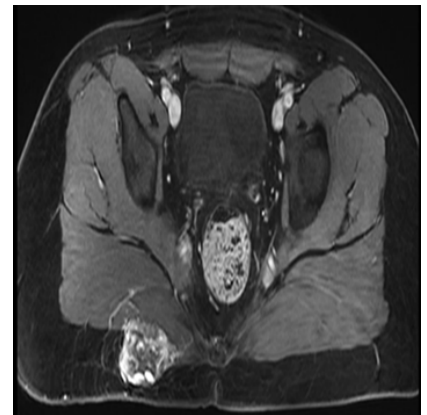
MRI enhanced scan image.
